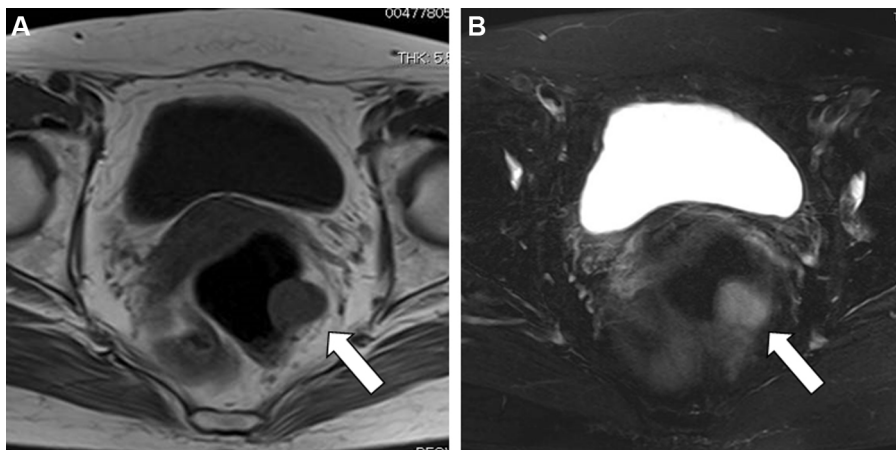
Magnetic resonance imaging. (A) Transverse T1-weighted image demonstrated a homogeneous mass without signal intensity (arrow). (B) Transverse T2-weighted image demonstrated a heterogeneous mass with high signal intensity (arrow).
